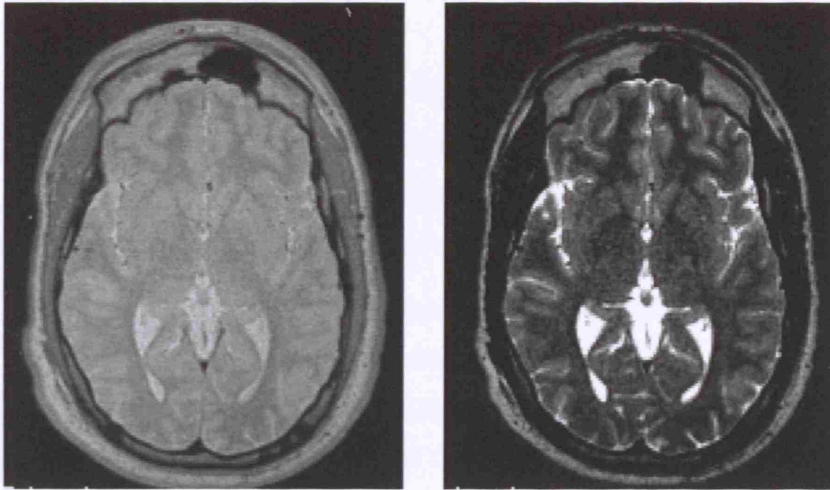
Example of images from a dual echo sequence. On the left is a slice from the first echo, in this case proton density weighted. On the right is the second echo image, a T2-weighted image.
